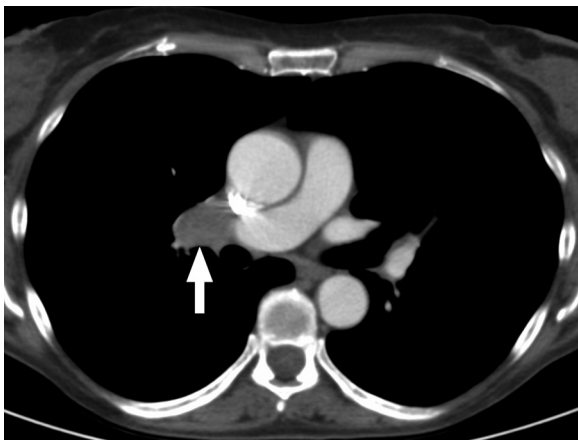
Axial contrast-enhanced computed tomography at the level of the hilum, in a patient with history of squamous cell carcinoma, showing right enlarged lymph node (large white arrow).
